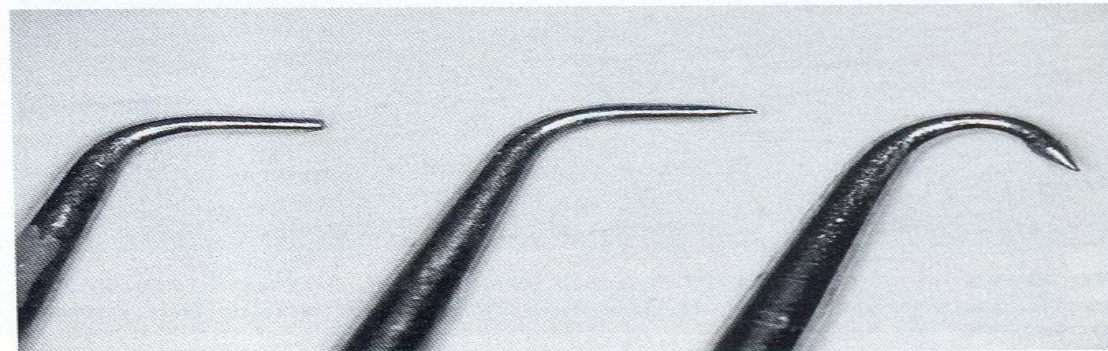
Enlarged view of ultrasonic tips. *Left*, CT 1. *Center*, CT 5. *Right*, Back-action (or CK).
